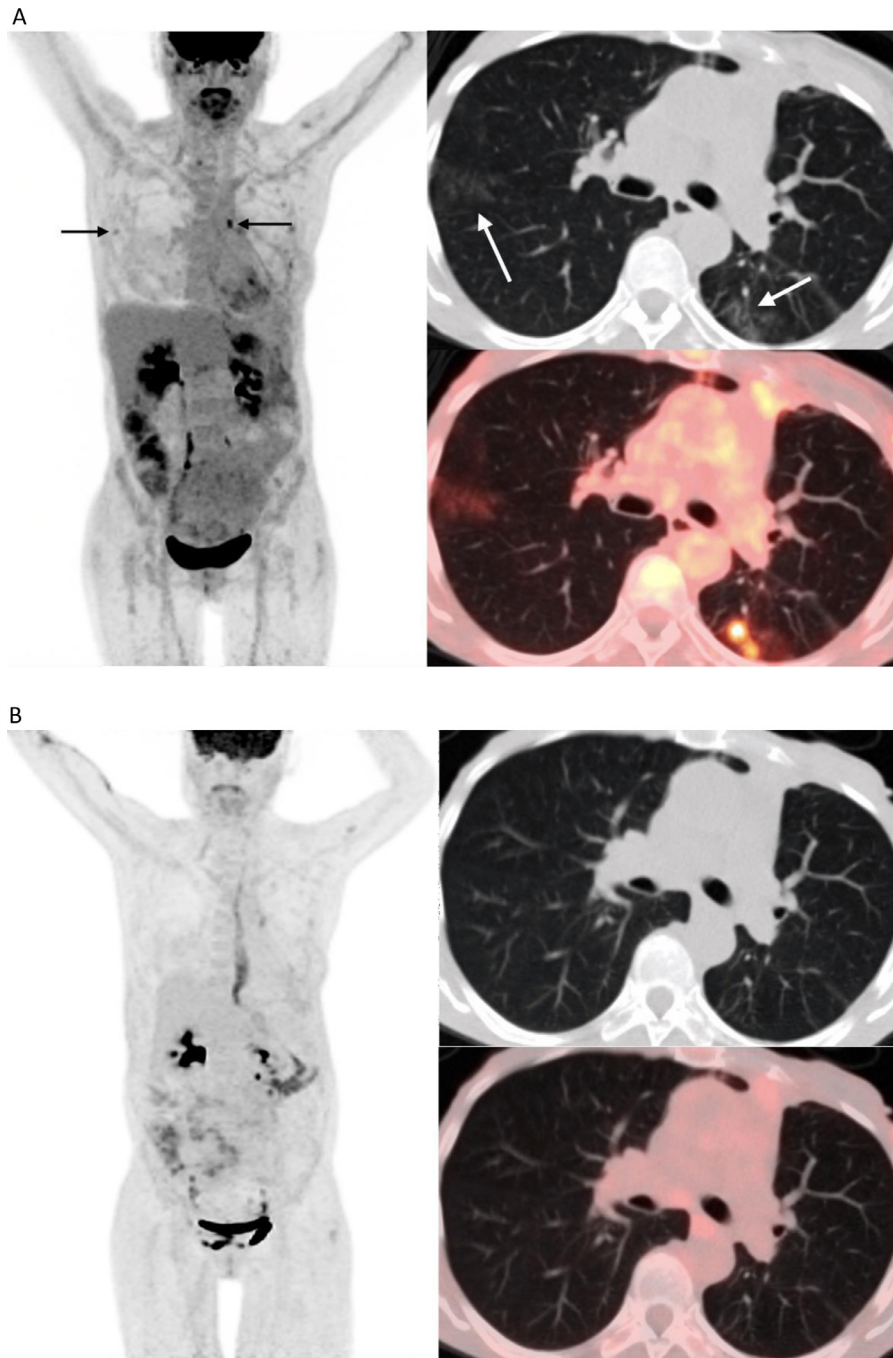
67-year-old female with lung adenocarcinoma on maintenance pemetrexed and bevacizumab presenting for routine PET/CT. (Panel A) MIP image shows foci of uptake in the bilateral chest (black arrows) corresponding to hypermetabolic peripheral ground-glass opacities (white arrows) in axial images. (Panel B) Follow-up PET/CT obtained four months after demonstrating complete resolution of lung opacities.
